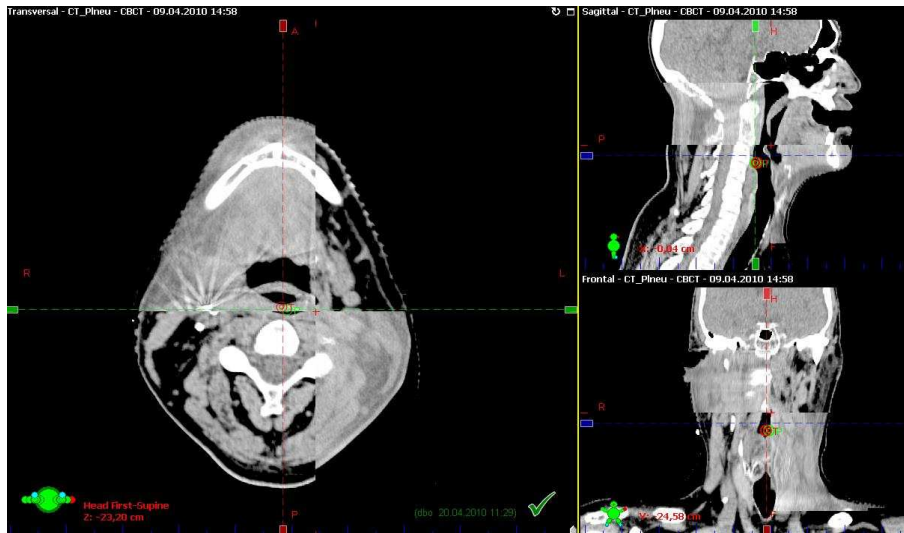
CBCT/Planning CT Image Fusion: Image obtained for one representative patient included in the study.
